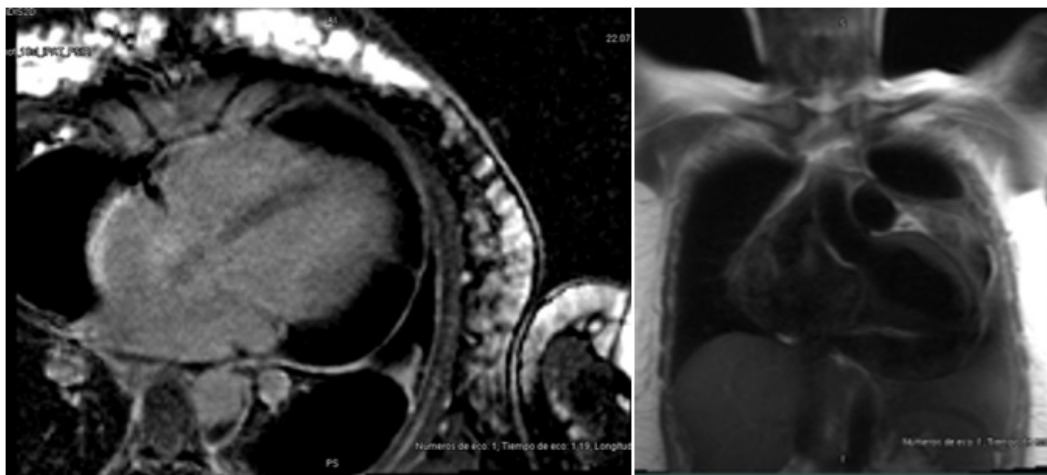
Cardiac magnetic resonance imaging showing cardiac chamber diameter and wall thickness within normal parameters, left ventricular systolic dysfunction, LVEF 38%, poor basal anterior intramyocardial (non-ischemic) late enhancement, pericarditis with significant pericardial effusion, loculated at the apical level, left pleural effusion.
